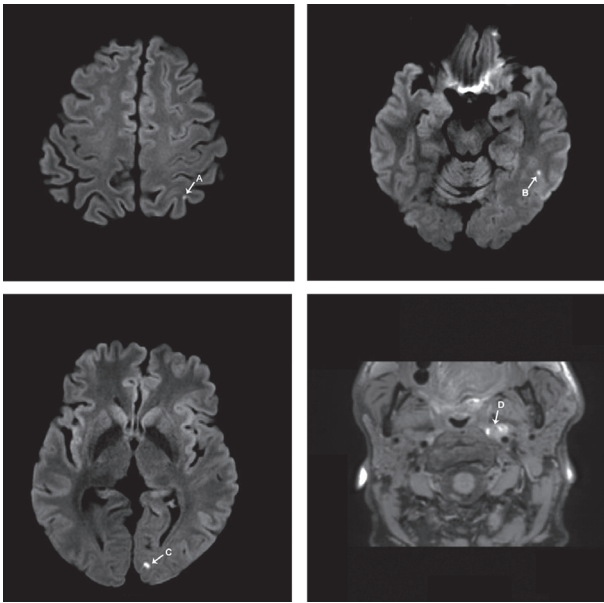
MRI of head and soft tissues of the neck performed the day after the traumatic event. The arrows show ischemic lesions in the left temporal (A), parietal (B) and occipital lobes (C) and a signal hyperintensity of the left internal carotid wall (D)
